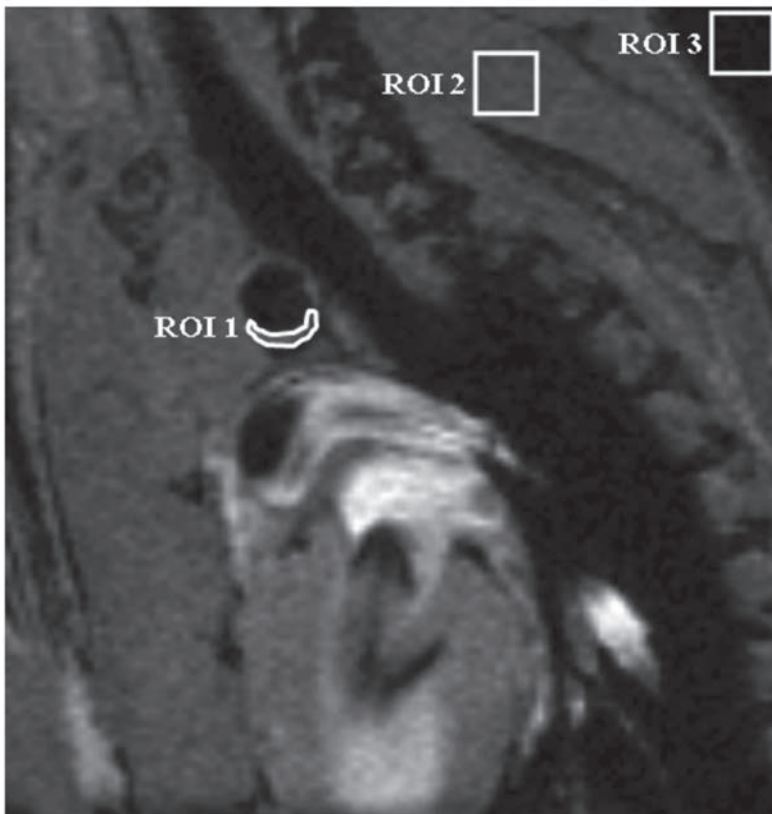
Contrast-to-Noise determination in the aortic arch. Region of interest (ROI) placement in the MR images were used to determine the contrast to noise ratios (CNR) in the atherosclerotic plaques in black blood images of a cross section of the aortic arch. ROI1 is placed in the atherosclerotic plaque in the vessel wall (I_{wall}). ROI2 is positioned in a muscle and used for normalization purposes (I_{muscle}). Noise levels were determined in ROI 3, placed in a region without signal. The standard deviation of the noise ($\text{stdev}_{\text{noise}}$) was used for normalization purposes.
